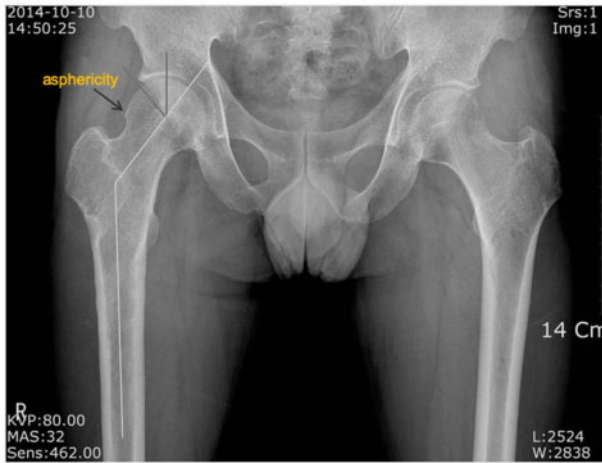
The CCD angle was 145°, the LCEA was 42° and asphericity was present on X-ray image.
